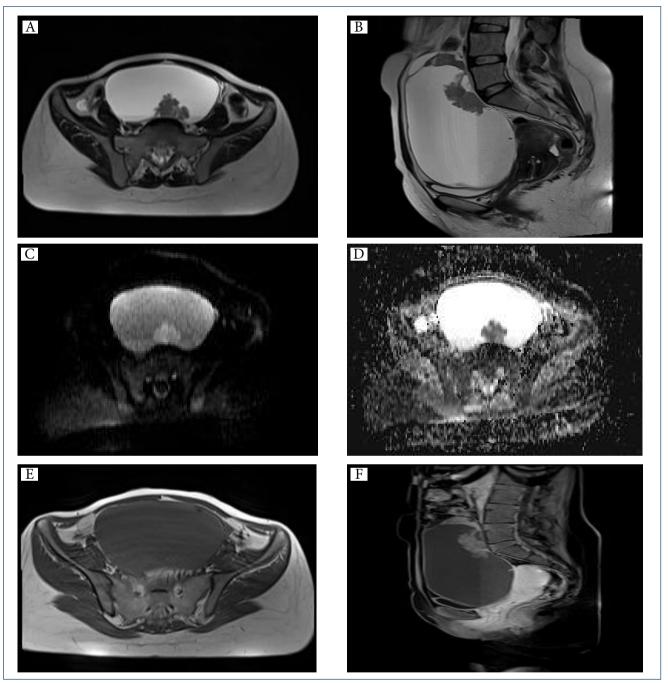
A 53-year-old woman with mucinous carcinoma. (A and B) Axial and sagittal T2-weighted image shows a gross multilocular cystic tumor with a mildly hyperintense mural nodule larger than 5 mm (arrow). (C) Diffusion-weighted image shows a hyperintense mural nodule (arrow). (D) Apparent diffusion coefficient (ADC) map shows a low ADC value. (E) T1-weighted image shows a hypointense mural nodule (arrow). (F) Contrastenhanced T1-weighted image shows a moderately enhanced mural nodule (arrow).
